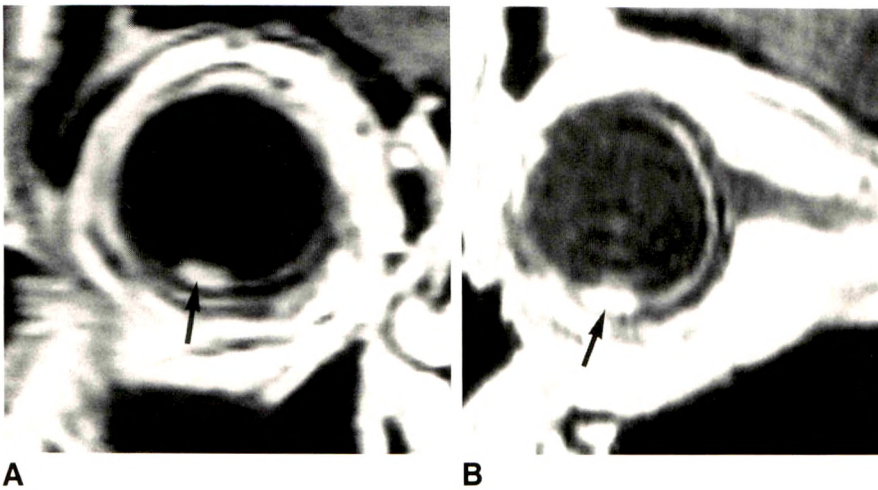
A and B, Coronal (A) and sagittal (B) postcontrast T1-weighted spin-echo MR images detected enhanced tumor (arrows) clearly.
